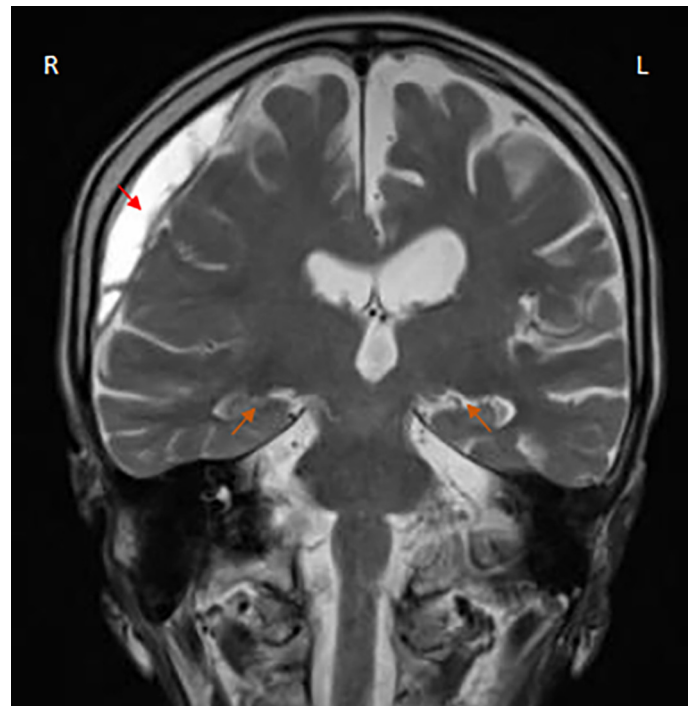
Brain MRI performed in November 2020 shows subdural hematoma (red arrow) in the right frontoparietal region and hippocampus was compatible with age (MTA score: 2) (orange arrows) on T2W-coronal section (13).
